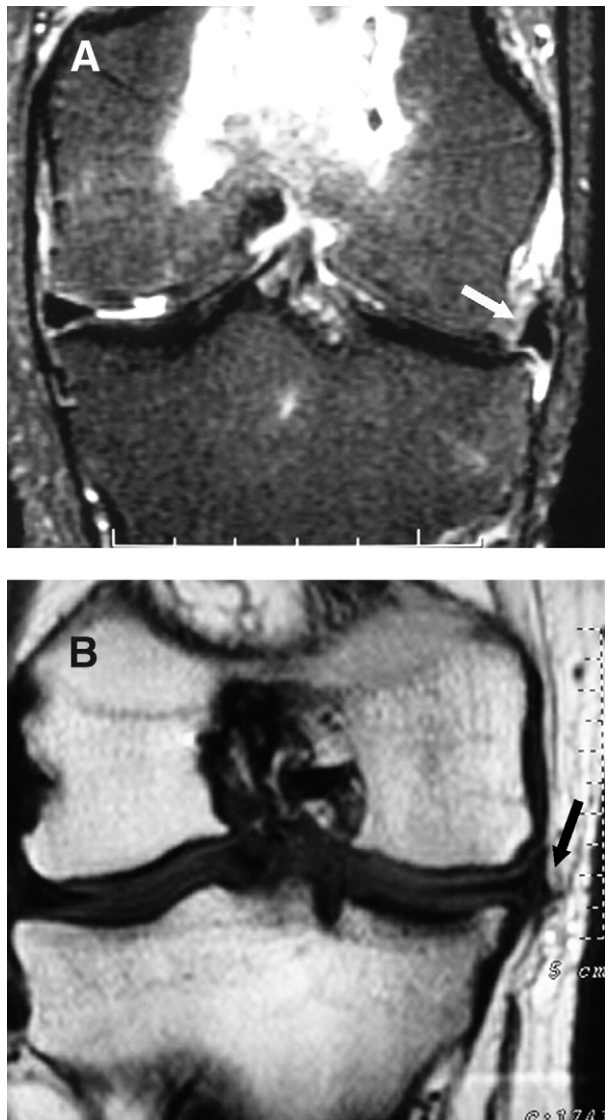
MRI coronal views of 2 knees after (A) lateral and (B) medial meniscal transplantation. A, Complete extrusion of the lateral allograft can be observed (white arrow). B, Partial extrusion of the transplanted meniscus behind the medial collateral ligament can be observed (black arrow).
